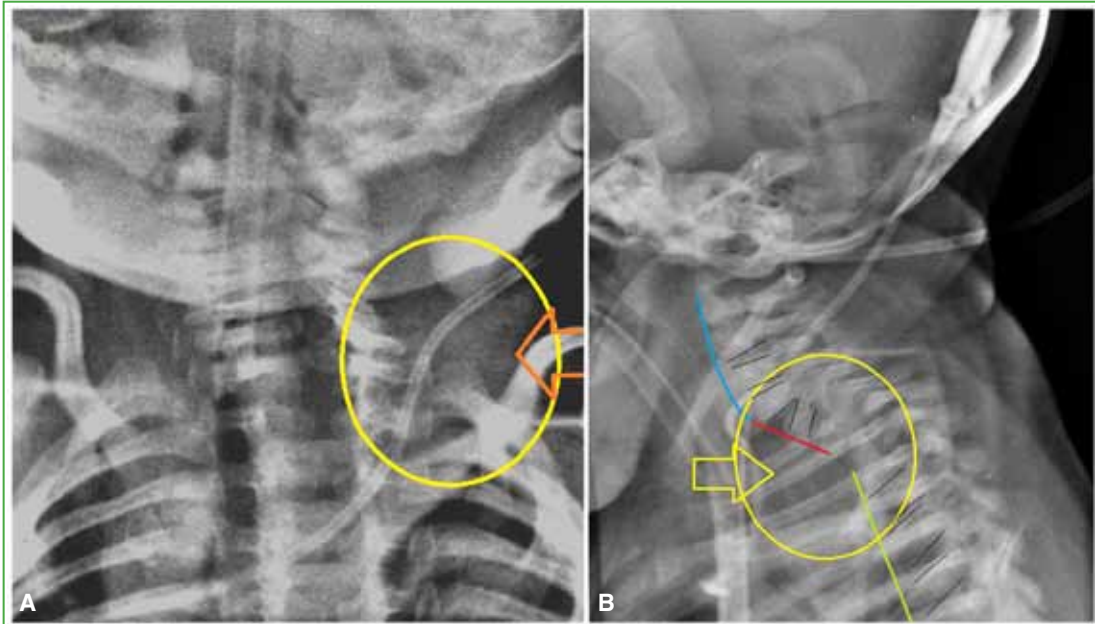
A. Anteroposterior thorax radiograph. Note the supraclavicular soft tissue mass (yellow circle, red arrow). B. Lateral cervical spine radiograph. Note the break in the alignment of the cervico-thoracic passage (red and green lines, circle and yellow arrow).
